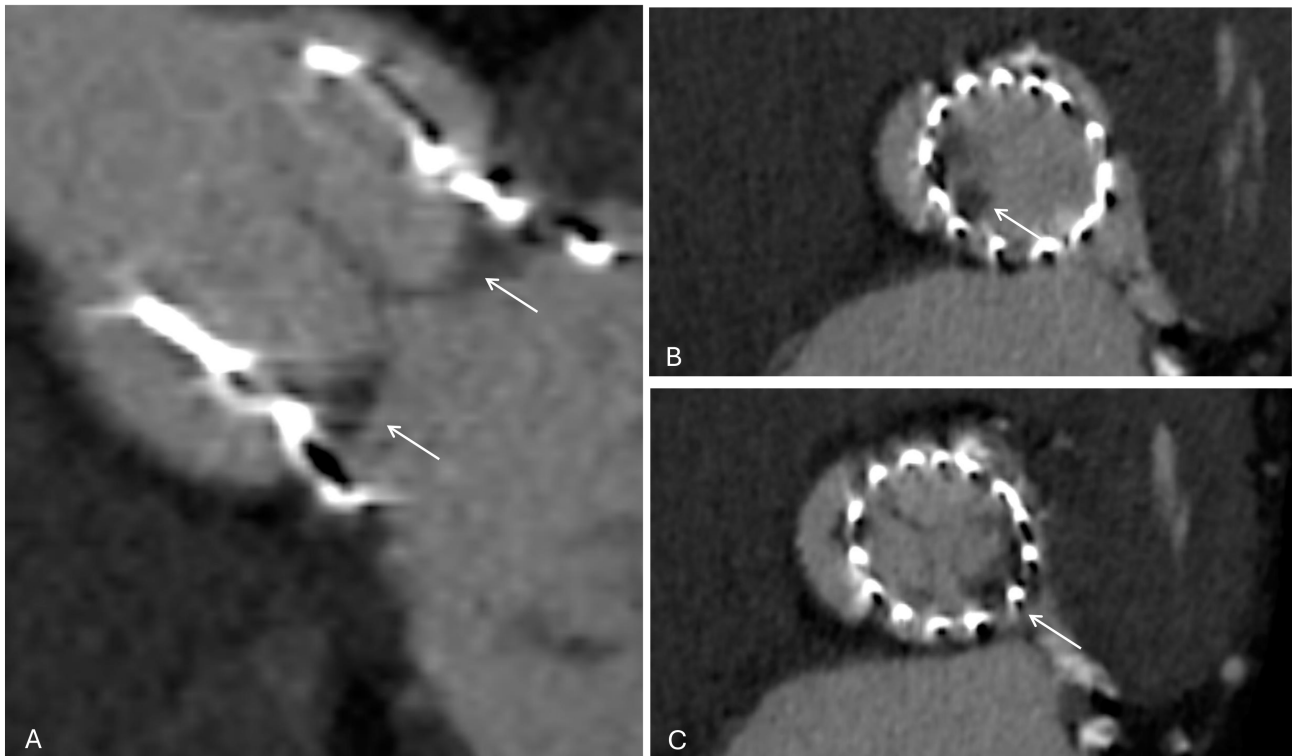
Cardiac CT demonstrating hypo-attenuated leaflet thickening (HALT) after TAVI. (A) Short-axis view of the transcatheter valve (white arrows). (B) At the mid-leaflet level, HALT is visible in the non-coronary cusp (white arrow). (C) At a slightly different reconstruction plane, HALT is instead visualized in the left coronary cusp (white arrows). These findings highlight how leaflet thrombosis can involve different cusps and may only be appreciable at specific imaging planes.
